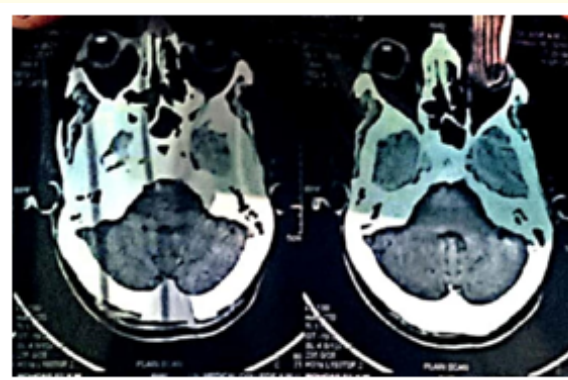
MRI showing extensive inflammation.
